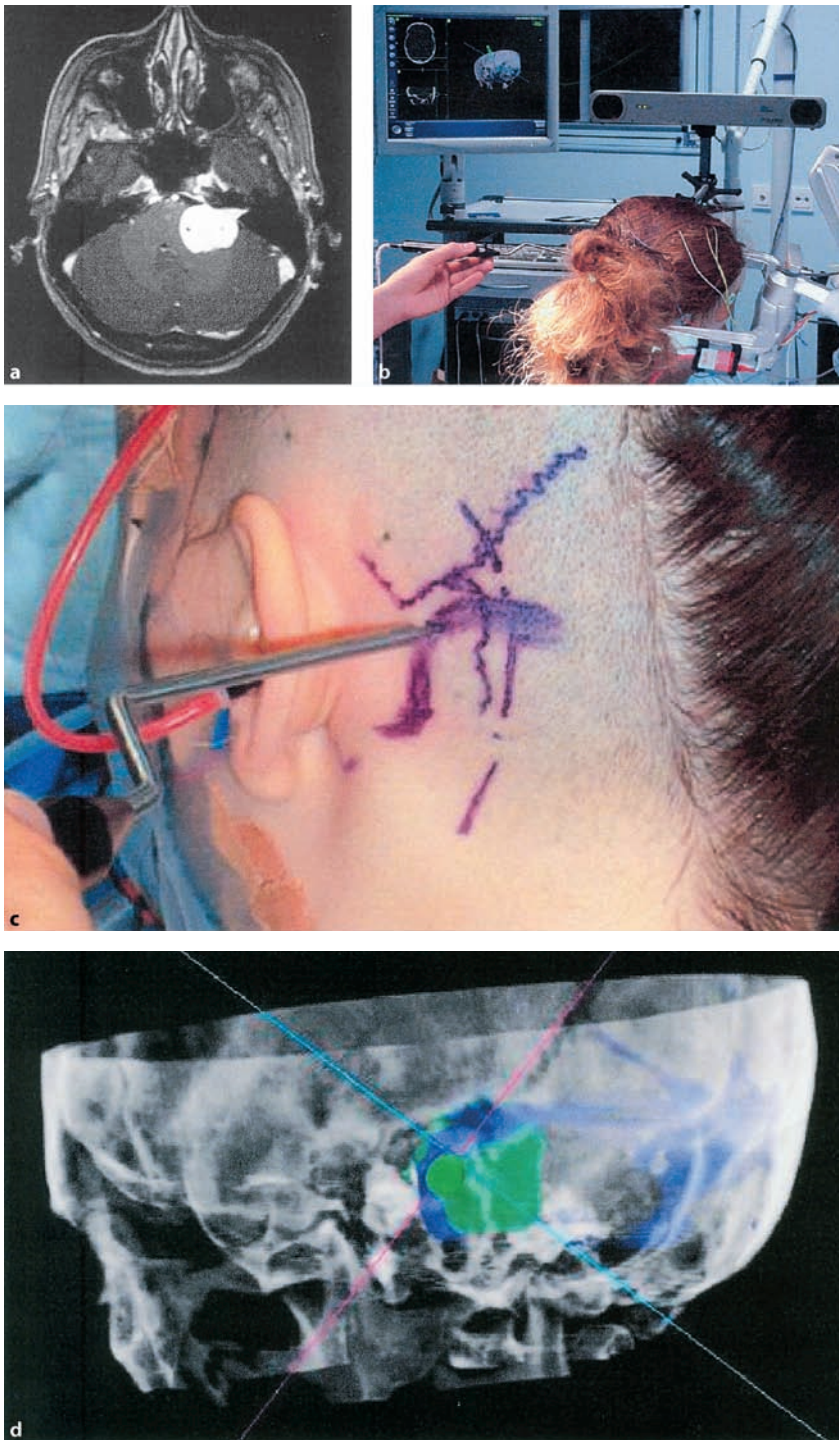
a Gadolinium-enhanced, T1-weighted axial MRI of a vestibular schwannoma on the left side. The primary data for image-guidance in this particular case were obtained from both a MRI and spiral computed tomography. b Semisitting position of the patient for the retrosigmoid approach. The infrared camera of the image-guidance system is placed low on the side of the lesion so that it can “see” the probe. c The course of the transverse and sigmoid sinuses and the bone sutures meeting at the asterion have been drawn to the skin with a surgical marker. d Corresponding image on the navigation screen with the virtual probe pointing to the transverse sigmoid transition
